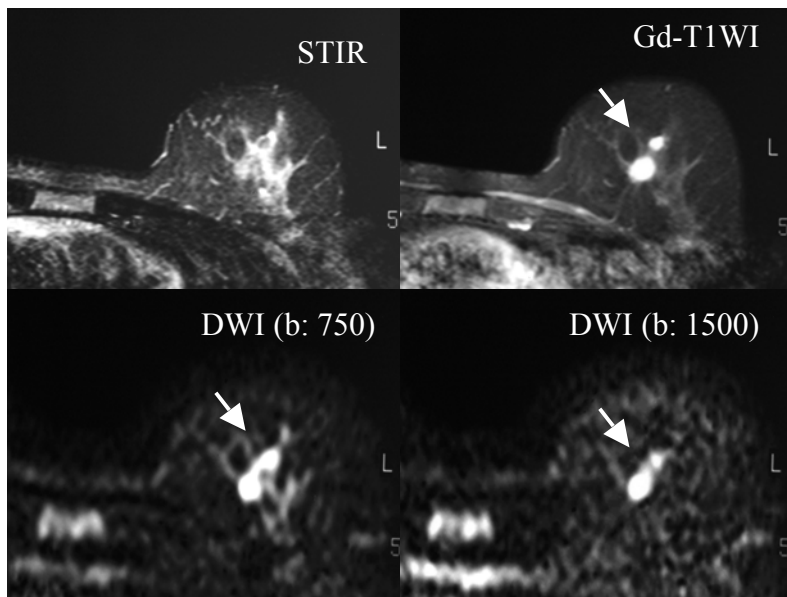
MR images of a ILC case
